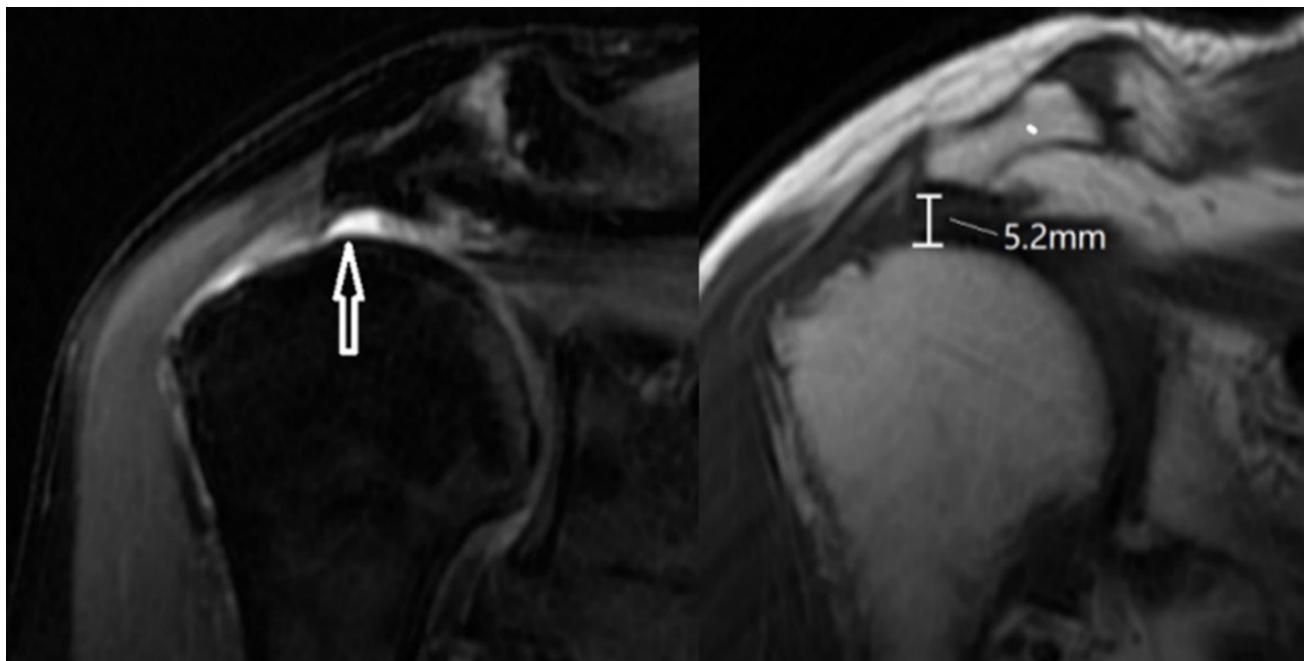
Acromiohumeral distance (AHD) measurement method. The shortest distance between the subchondral bone plate of the humeral head and the cortical margin of the acromion was measured on coronal oblique T1-weighted MRI images (as shown in the left image). Additionally, the extent of the supraspinatus tendon injury was assessed on coronal oblique MRI proton density-weighted (PD-weighted) images. A full-thickness tear of the distal supraspinatus tendon is indicated by the arrow in Fig. 2.
